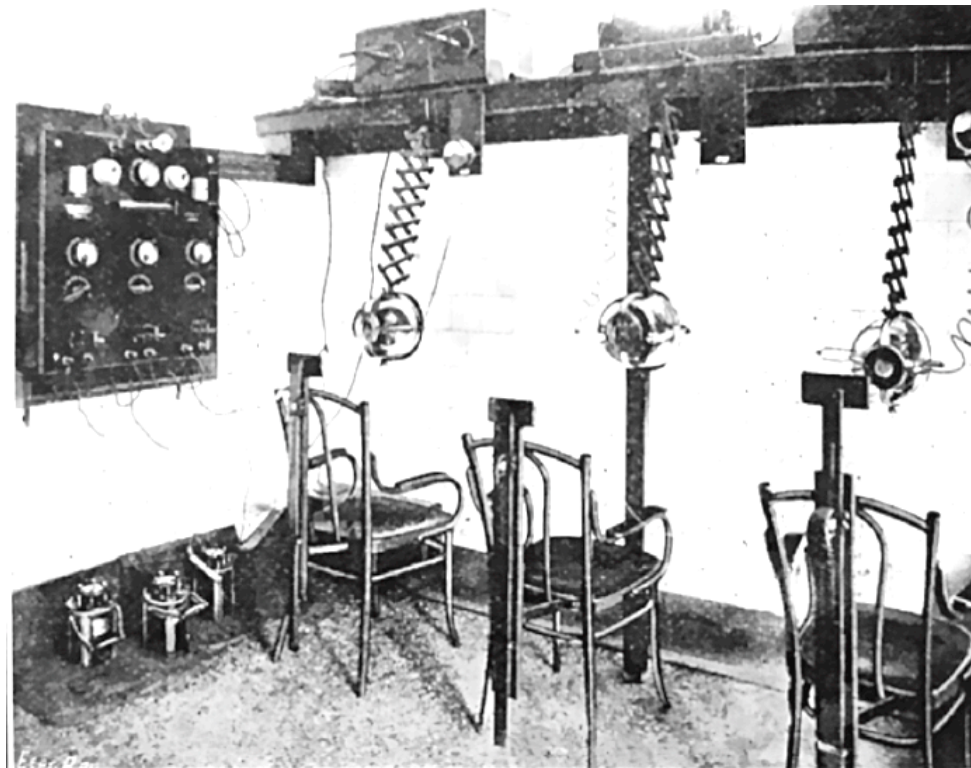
X-ray therapy for ringworm at the London Hospital (1905).²⁴⁴
